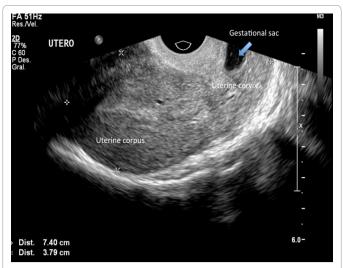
Vaginal sonogram showing uterine corpus and cervix, where a gestational sac is identified in the latter.
